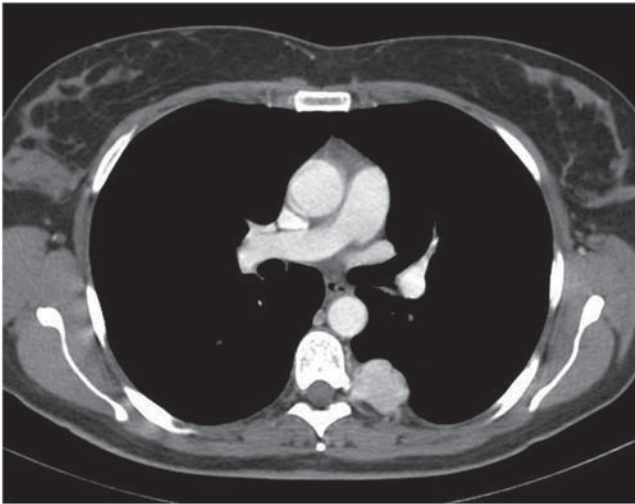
CT-scan of the chest showed a multilobulated solid lesion of 33×20×30 mm in the posterior mediastinum, partly involving the lateral foramen. The lesion appeared without calcification and with homogeneous contrast enhancement. CT, computed tomography.
